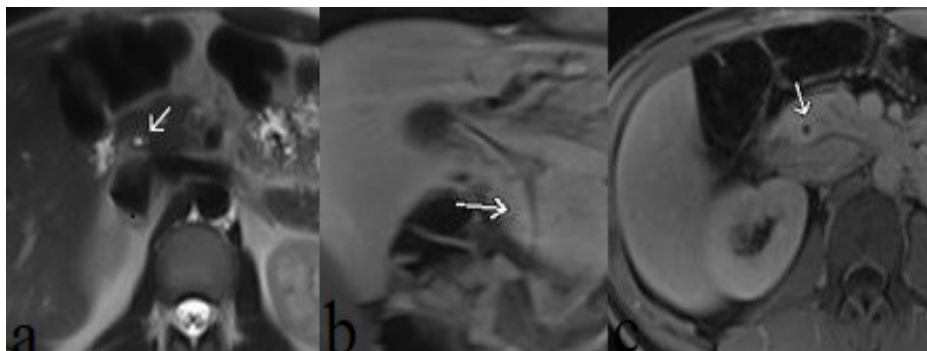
A male patient, age 35, was diagnosed with acute cholangitis. The axial T2-weighted (a) image shows an increased periductal signal intensity with wall thickening (white arrow). On contrast-enhanced coronal (b) and axial (c) MRI sequences, increased enhancement is seen (white arrows).
